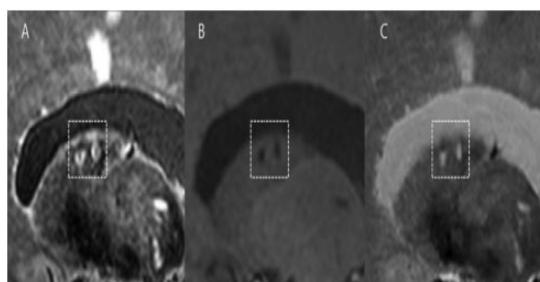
Two cavitated small infarcts in the body of the left caudate nucleus in a 67-year-old female shown on sagittal FLAIR (A), T1-weighted (B) and T2-weighted images (C). These lesions are hypointense with a hyperintense rim on the FLAIR image, hypointense on the T1-weighted image and hyperintense on the T2-weighted image.
